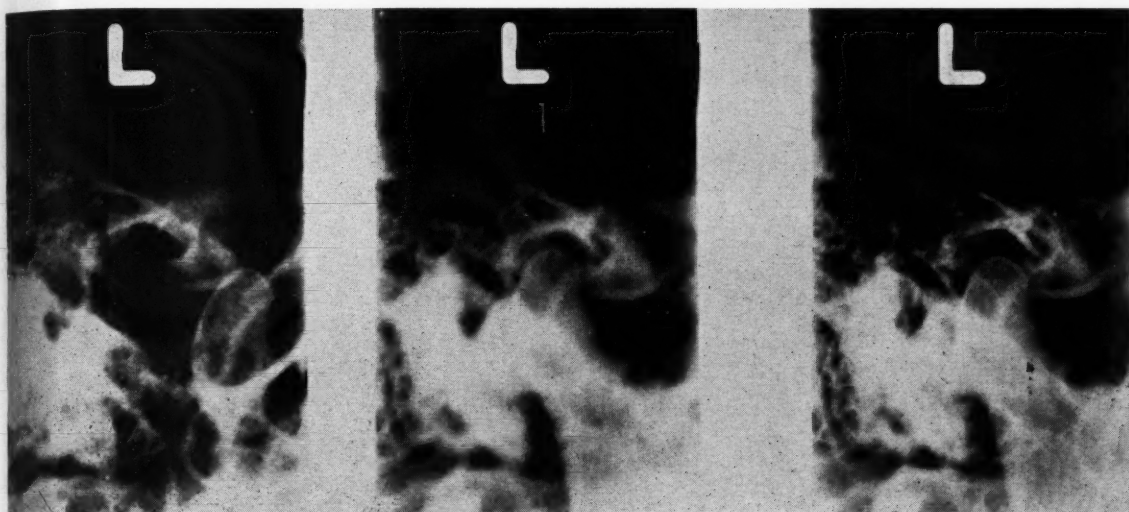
X-ray of a condyle in rest, closed, and open position. In the translation to open position the condyle is in front of and below the articular tubercle.
